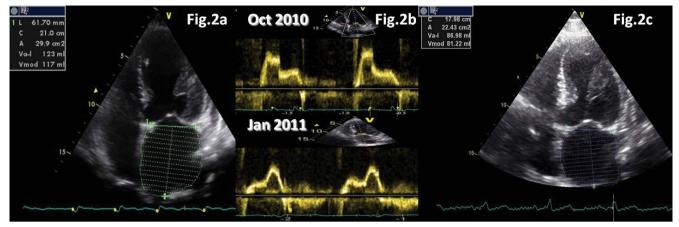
Echocardiography essentials: a. September 2010 - severe LA dilatation (LA volume 123 ml); b. diastolic filling profile improvement: from type III - restrictive filling (October 2010) to type I - impaired relaxation (January 2011); c. LA volume 86 ml in January 2018.
